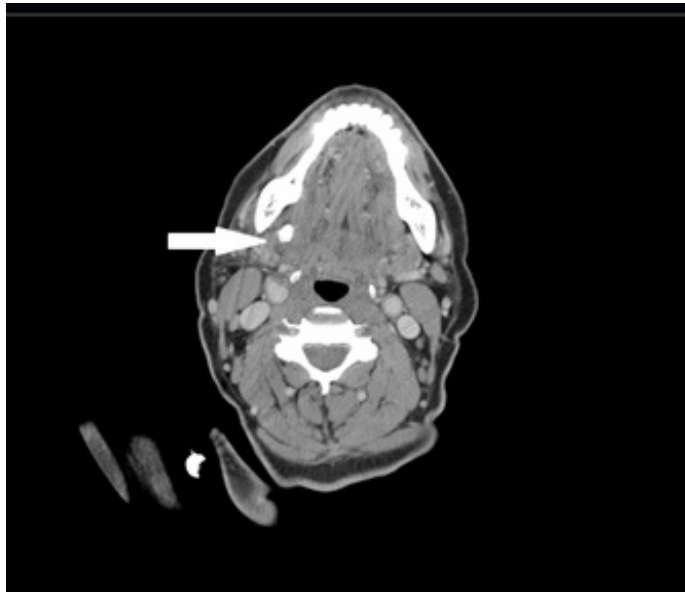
Computed tomography image of an eight millimeter stone within the right Wharton's duct (arrow).
